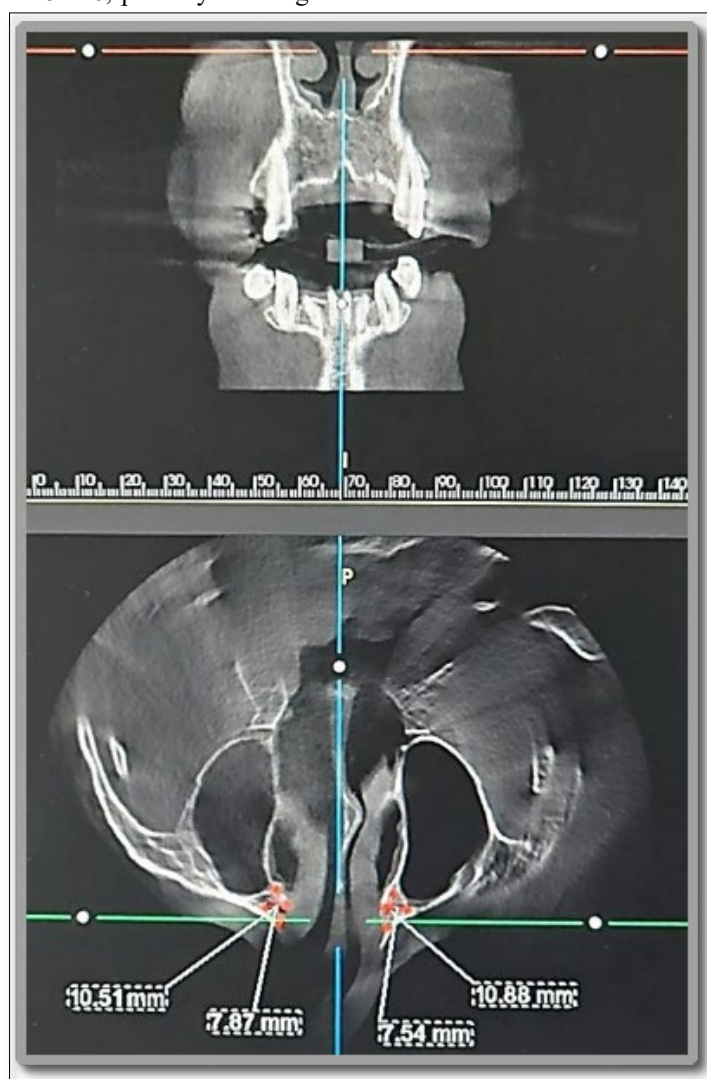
CBCT assessment of bone availability and maxillary sinus pneumatization.
